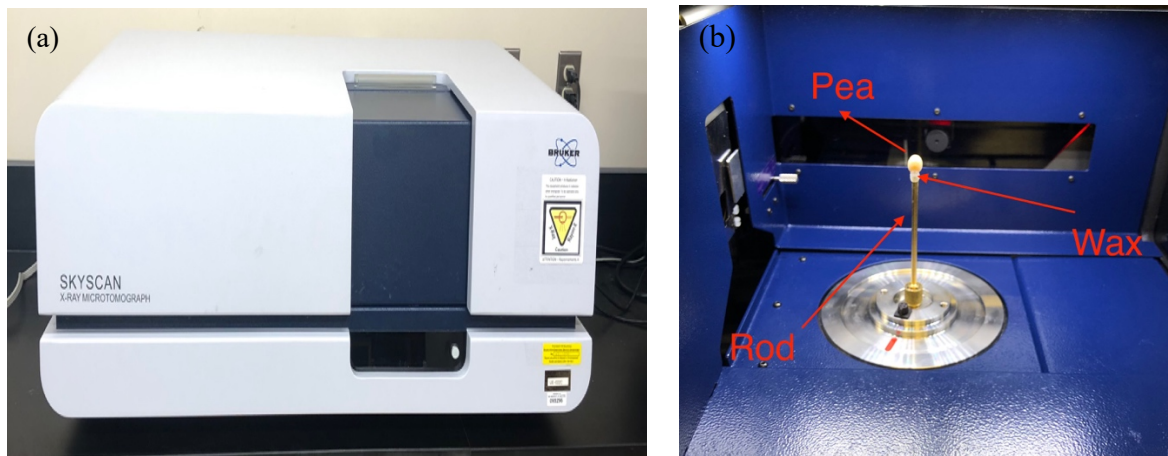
4. (a) Skyscan X-Ray microtomography (b) an individual pea was mounted on a sample holder rod and glued with a thin layer of low-density wax.
